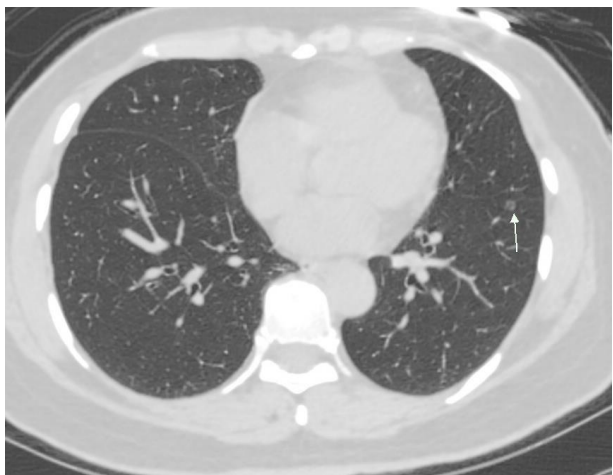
A 47-year-old female patient with influenza B. Computed tomography scan showed simple ground-glass opacity (indicated by arrows).
